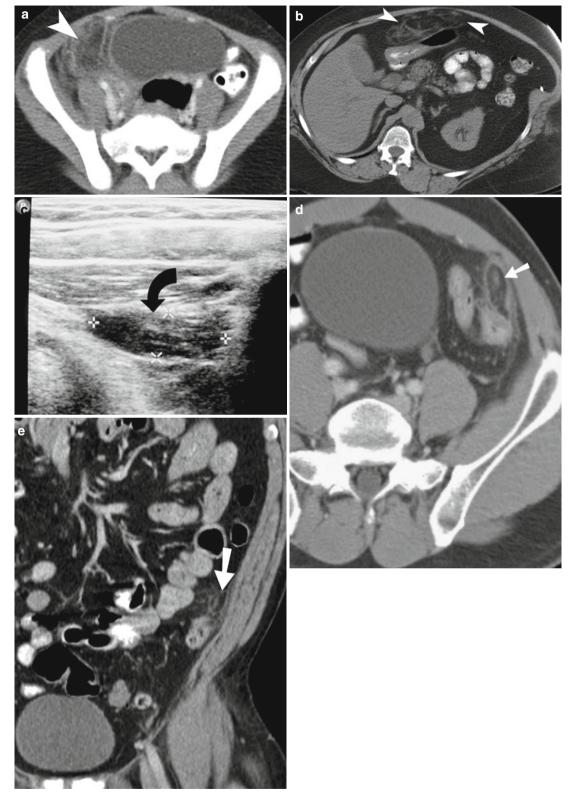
Segmental omental infarction (a, b) and acute epiploic appendicitis (c–e). (a) Contrast-enhanced CT scan study demonstrates a 7-cm-diameter omental fat density inflammatory lesion (*arrowhead*) in the upper right lower quadrant of the abdomen of a 6-year-old patient. (b) Noncontrast CT of a patient with segmental omental infarction demonstrates a midline inflammatory fatty lesion anteroinferior to the left lobe of the liver. (c) Ultrasound of a patient with acute epiploic
